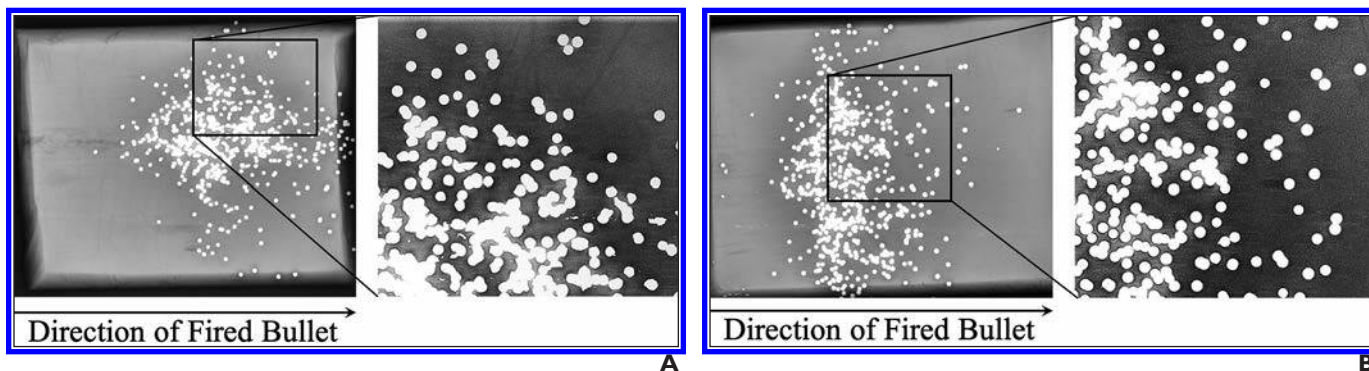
Radiography of shotgun ammunition fired into ballistic gelatin blocks.
